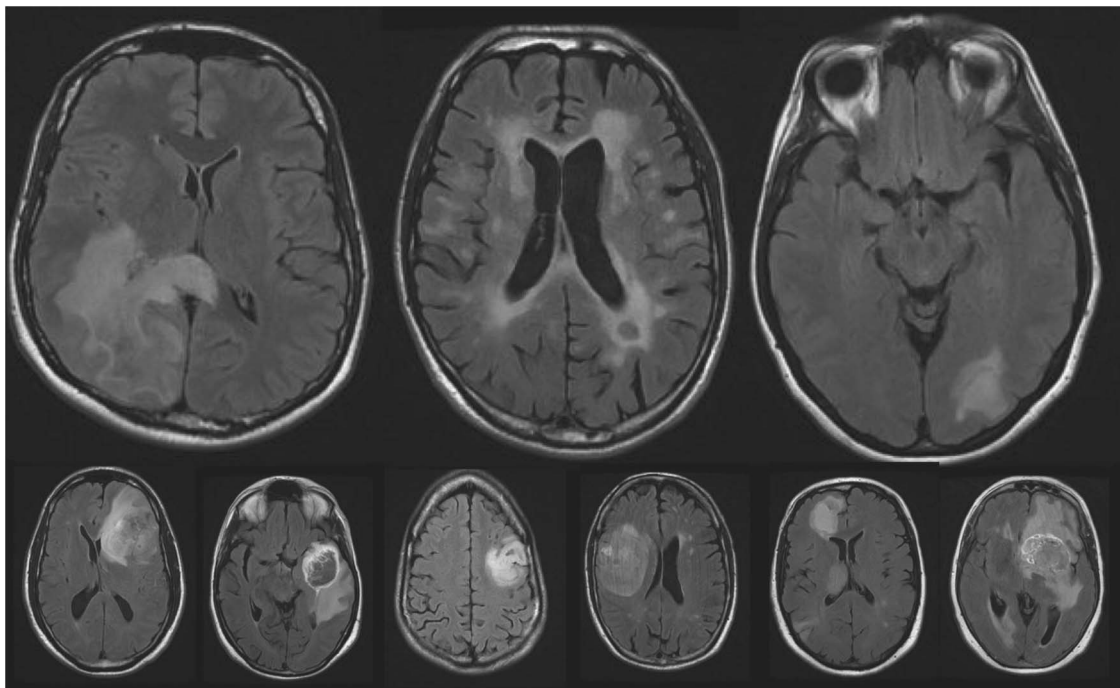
MRI T2 FLAIR of all individuals with a TDL (top) or HGG (bottom).
